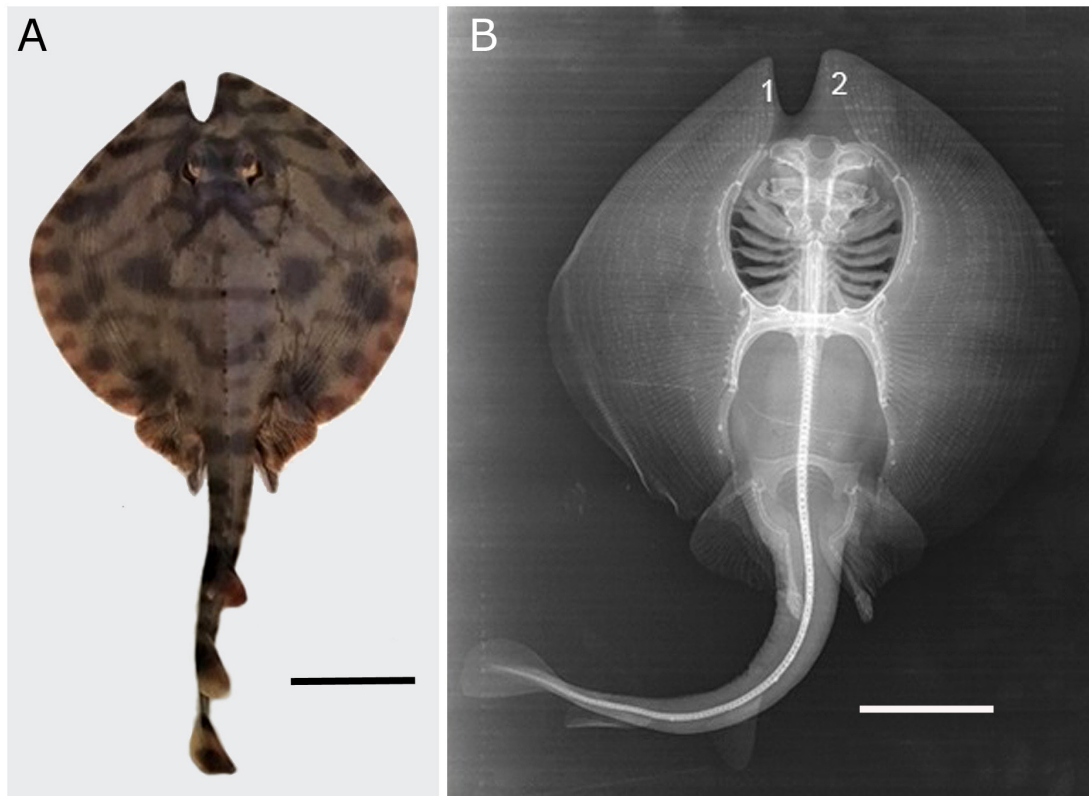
Zanobatus schoenleinii* (Ref. ISPAB-Zan-sch-03). A. Dorsal surface exhibiting a pectoral non-adherent to the head, scale bar= 80 mm. B. X-ray radiography, showing the rostrum divided into a left margin (1) and a right margin (2), scale bar= 70 mm / *Zanobatus schoenleinii* (Ref. ISPAB-Zan-sch-03). A. Superficie dorsal exhibiendo la aleta pectoral no adherida a la cabeza, barra de escala= 80 mm. B. Radiografía, mostrando el rostro dividido en un margen izquierdo (1) y un margen derecho (2), barra de escala= 70 mm
